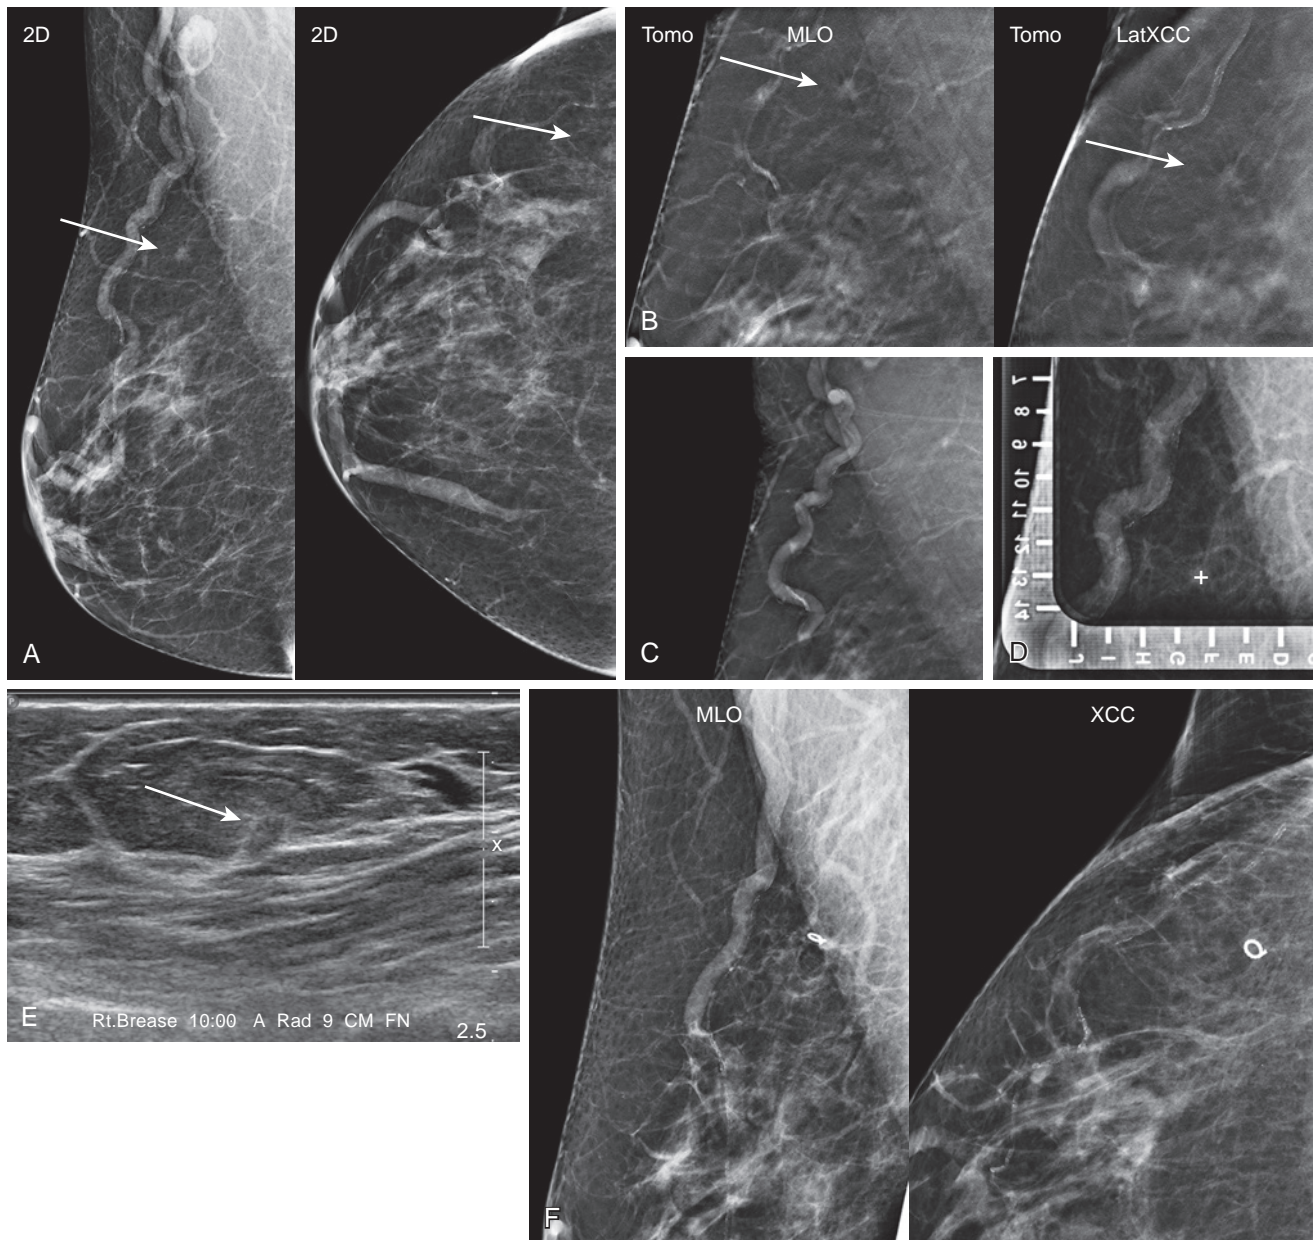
(A) A small mass (*arrows*) was noted on a screening exam in a 66-year-old woman. (B) The tomosynthesis images in MLO and laterally exaggerated CC views show spiculated margins not apparent on 2D imaging. No ultrasound correlate could be found. Stereotactic biopsy was attempted at another facility, but the area could not be successfully targeted. (C) The patient returned to our facility 4 months later, when the lesion was again noted, but again no sonographic correlate could be initially identified. (D) A spot tomosynthesis image was obtained with the open window paddle against the lateral breast, and the alphanumeric area (F-13) was identified and marked with a permanent marker on the skin. (E) The patient was then taken back to ultrasound, where a very subtle isoechoic sonographic finding was successfully identified. (F) Post-ultrasound-guided biopsy shows the lesion to be mostly removed and the biopsy marker in the expected location. Pathology on core biopsy and surgical excision revealed well-differentiated invasive ductal carcinoma. ER+/PR+/Her2-.
